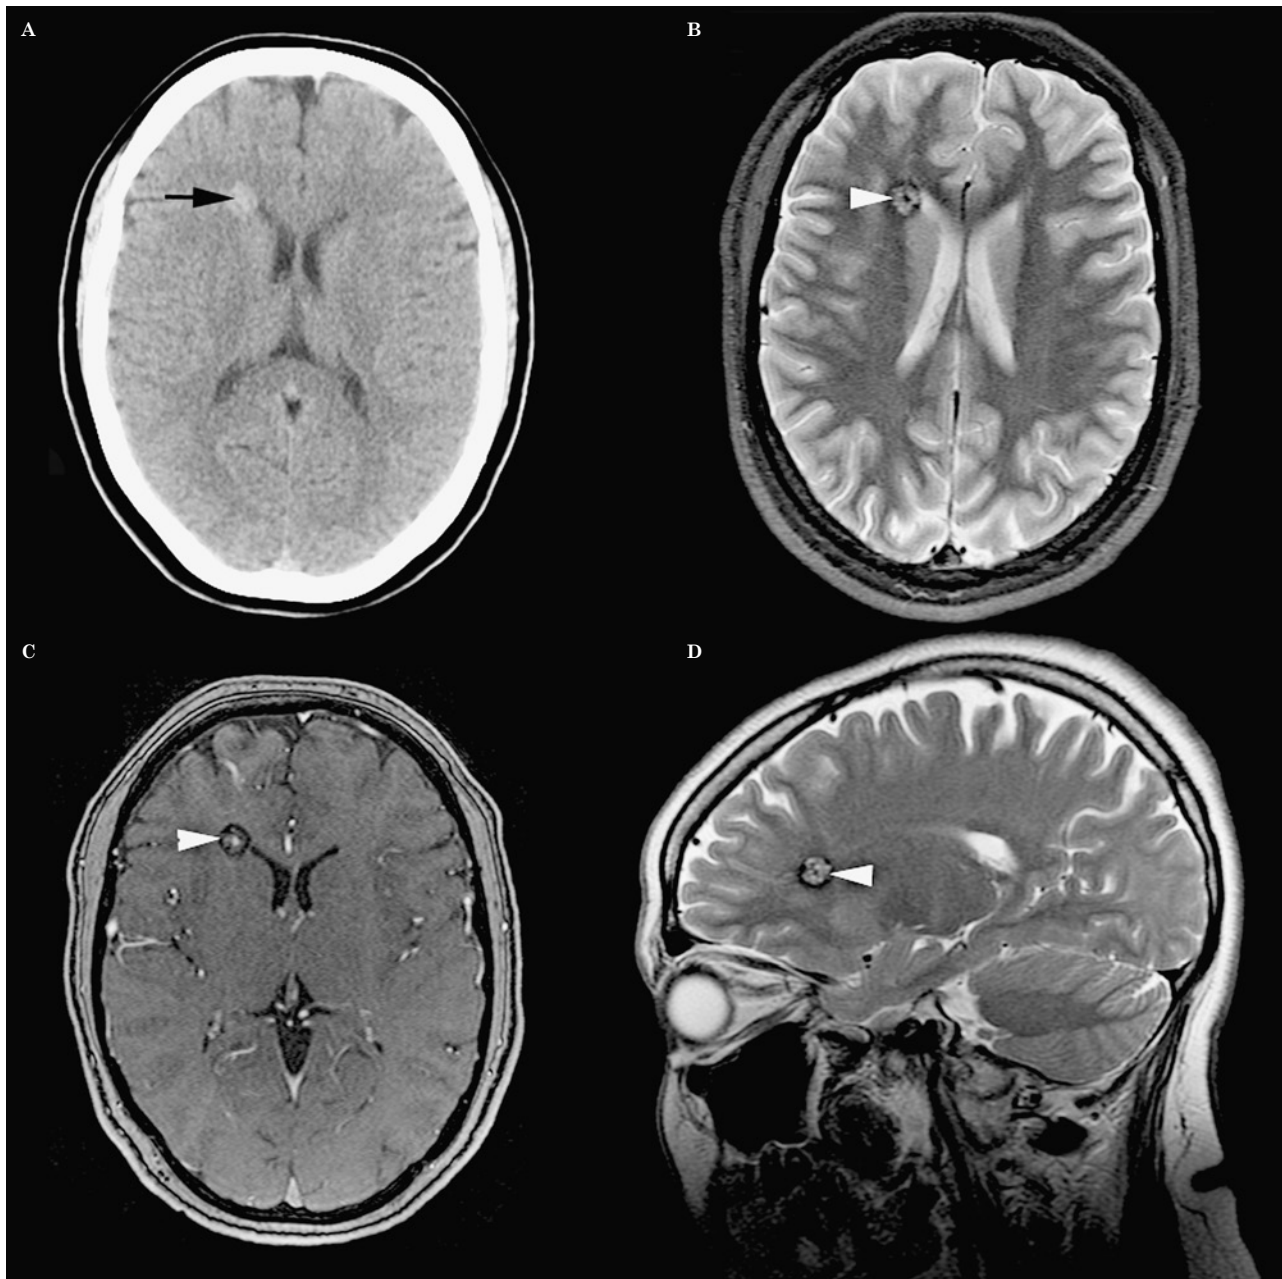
Cavernous angioma. A) Unenhanced CT demonstrates a well-defined hyperattenuating lesion (arrow) just lateral to the frontal horn of the right lateral ventricle. Areas of calcification and haemosiderin deposits, combined with the increased blood pool within the lesion, are responsible for the hyperattenuation on non-enhanced CT images. Axial T2W (B), axial T1W (C) and sagittal T2W images (D) demonstrate the characteristic 'popcorn ball' appearance (arrowheads) of mixed hyper-, and hypo- intense blood-containing locules.
